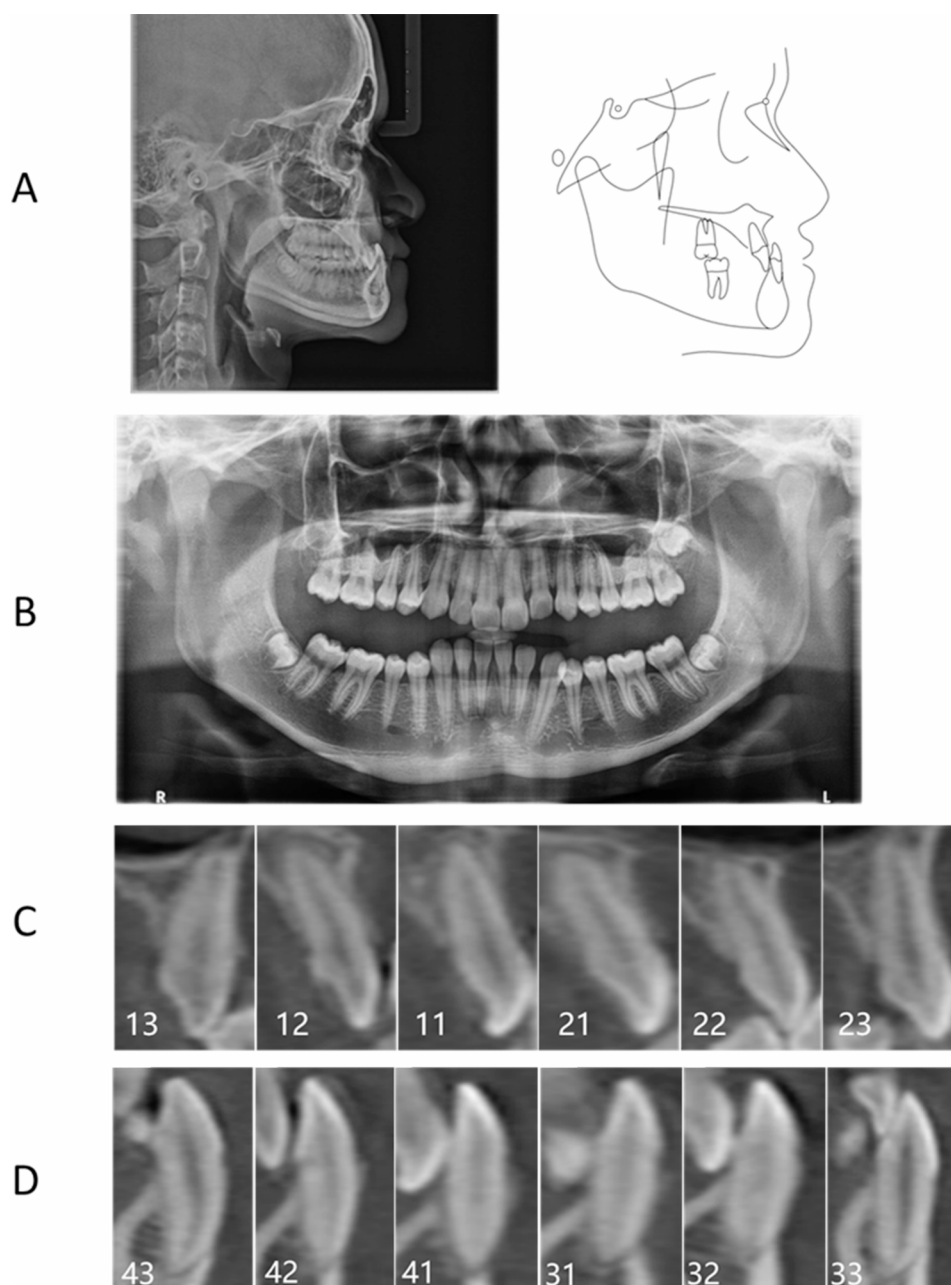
(A) Pretreatment lateral cephalometric radiograph; (B) panoramic radiograph; (C) CBCT imaging of the maxillary anterior area; and (D) CBCT imaging of the mandibular anterior area taken at the initial visit
